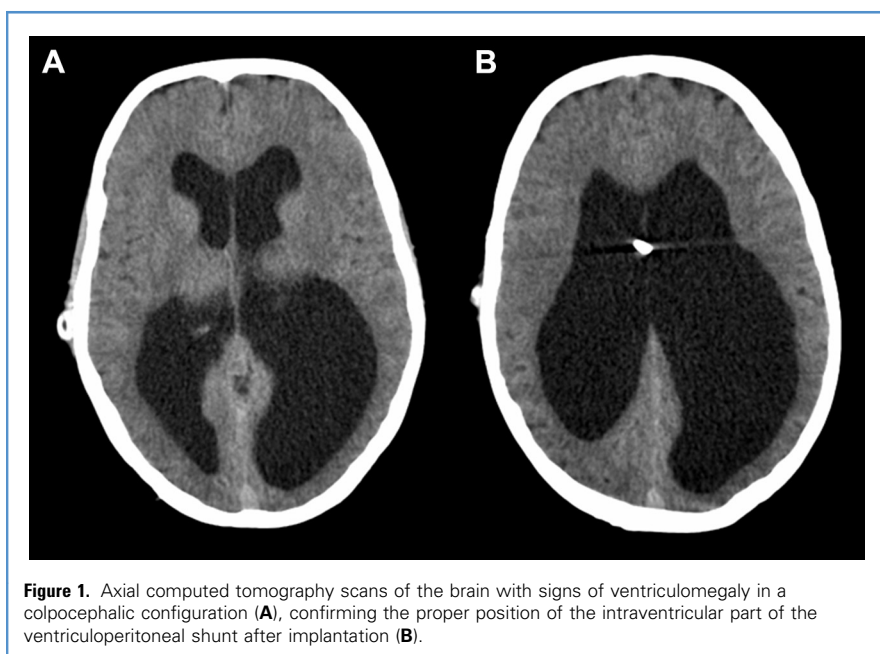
Axial computed tomography scans of the brain with signs of ventriculomegaly in a colpocephalic configuration (A), confirming the proper position of the intraventricular part of the ventriculoperitoneal shunt after implantation (B).
